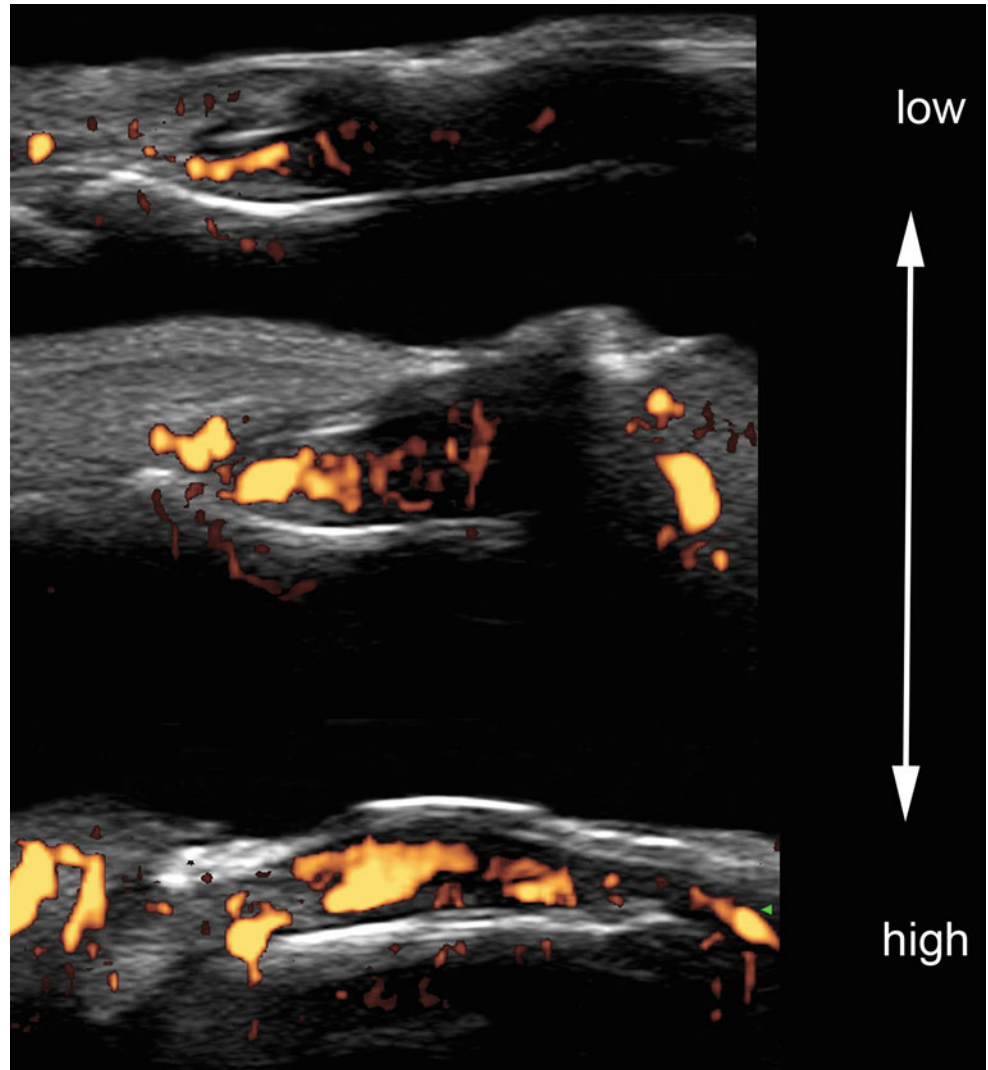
Psoriatic onychopathy blood flow patterns. Power Doppler ultrasound image (longitudinal views) shows the variable degrees of blood flow in the psoriatic nail bed going from a low (partial and proximally located) to high level (total and diffuse) of vascularity within the nail bed
